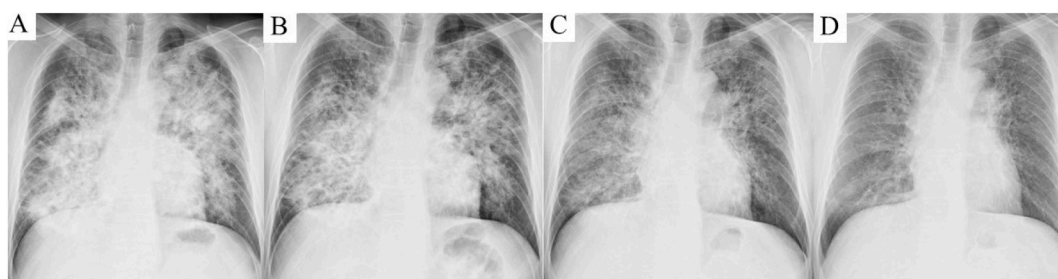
Chest radiographs taken during and after the course of treatment. Chest radiographs obtained (A) on admission; (B) a week following the administration of trimethoprim and sulfamethoxazole; (C) at the end of the treatment; and (D) 5 weeks following treatment completion.
